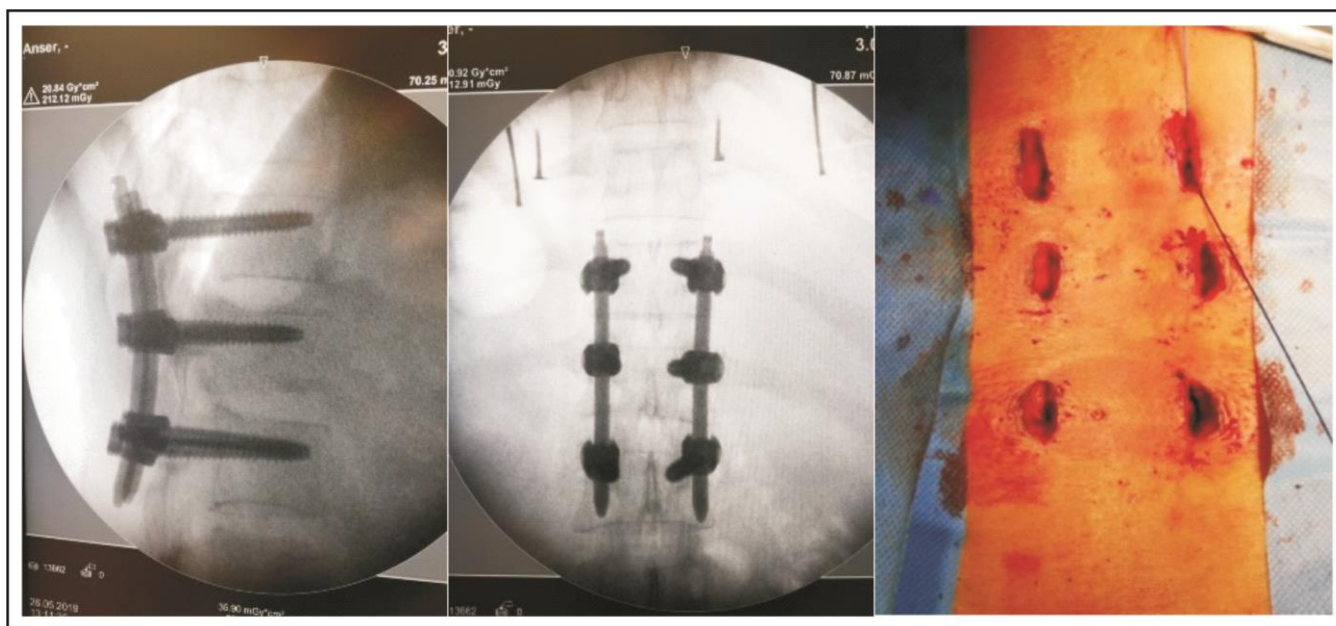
shows X-rays (AP and Lateral views), CT scans, and MRI of a D12 burst fracture. MRI highlights the cord compression. Figure 2a shows tapping of D12 pedicles with Jamshedi needles under fluoroscopic AP views, Figure 2b is showing the guide wire passed through pedicles into the D12 vertebral body, Figure 2c shows tapping of the pedicle and vertebral body as seen in lateral views of fluoroscopy and Figure 2d is transpedicular screws in AP view. In Figure 3, lateral and AP fluoroscopic views show stabilization of fractured vertebra with transpedicular screws and rods. The last image (3c) shows the minimal skin incisions used in the surgery.
